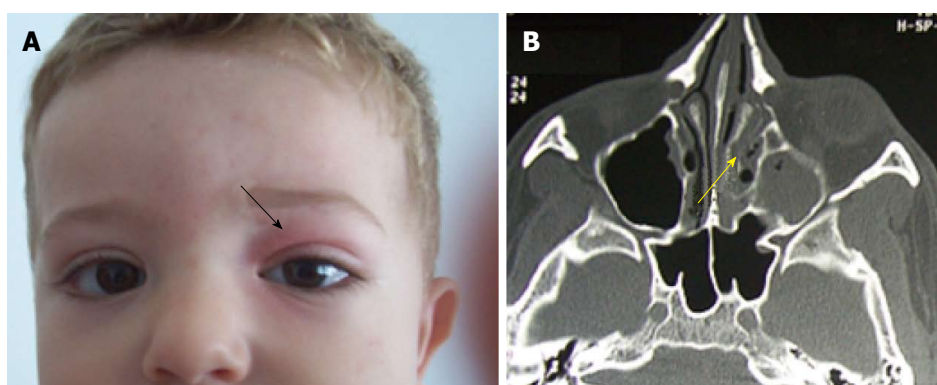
Swelling and redness at the level of the left upper eyelid (A); the computed tomography-scan shows a fulfilling of the ethmoid cells and the left maxillary sinus (B).
